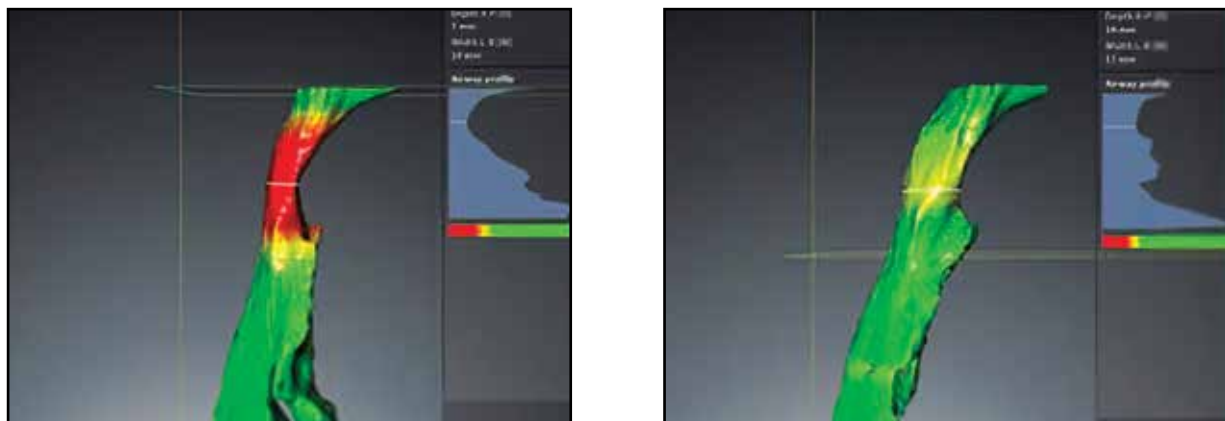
Patient CBCT images taken before (left) and after (right) the treatment. The airway volume increased by 14% from 18,972 mm³ to 21,692 mm³, and the minimal cross-sectional area doubled from 76 mm² to 156 mm².
